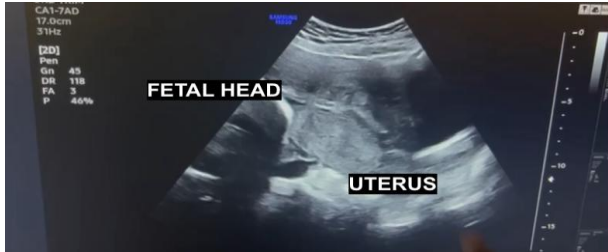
Ultrasound showing disrupted uterine contour with fetus visualized outside the uterus, consistent with uterine rupture.
